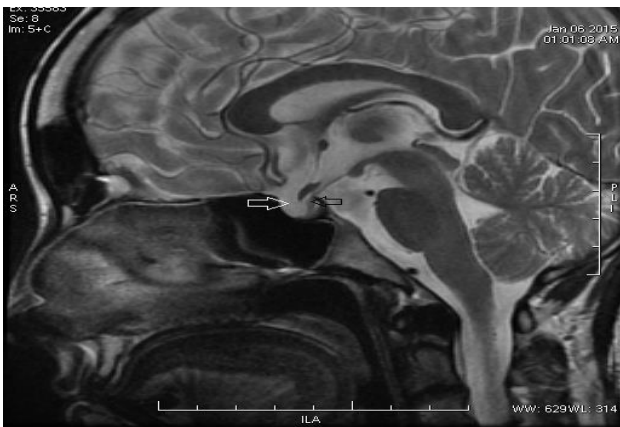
Sagittal t2 weighted MR image shows sella turcica is replaced by CSF intensity, which appears hyperintense on t2 weighted images (open white arrow) with posteriorly compressed pituitary gland which appears iso intense on t2 weighted images (open black arrow).
